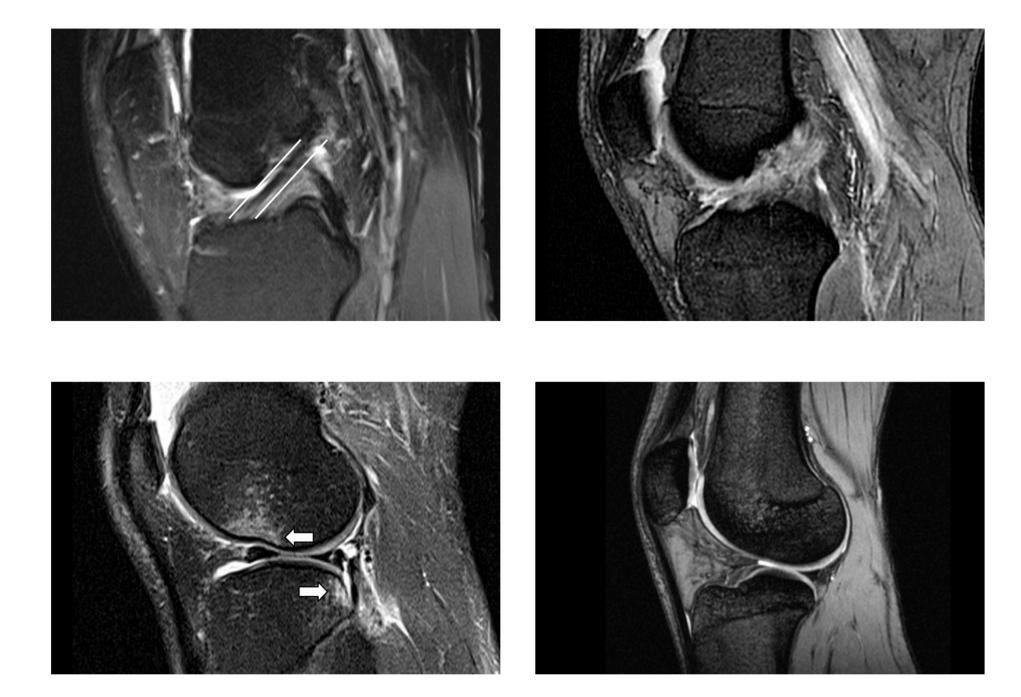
MRI images of a normal ACL (between white lines), ruptured ACL (ligament not clearly visible), bone marrow oedema (white arrows) and anterior tibial translation.
